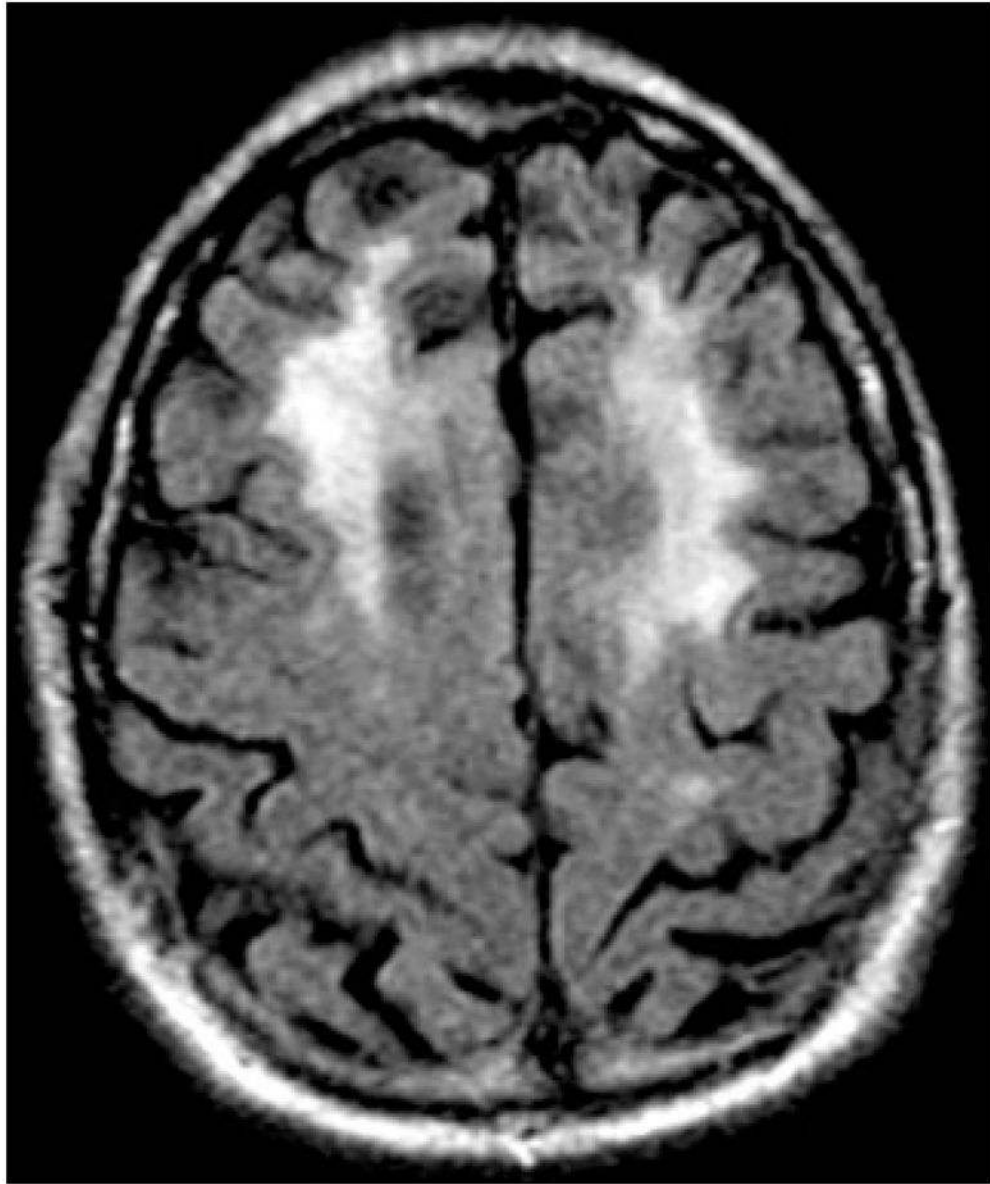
FLAIR MRI showing hyperintensities in prefrontal white matter in a patient with HIV and cognitive impairment.²
